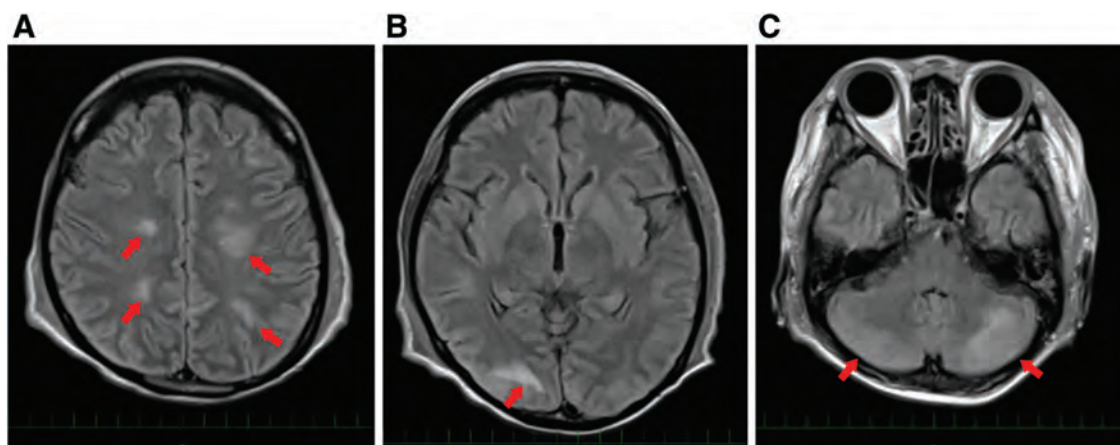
Magnetic resonance imaging findings of PRES
